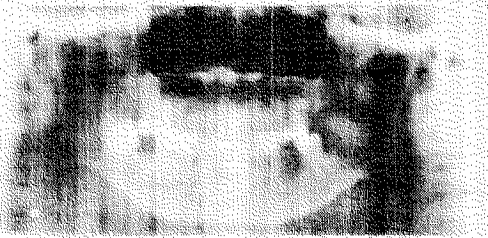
Panoramic Radiograph of the Mandible showing cystic lytic lesion on the left hemimandible.
